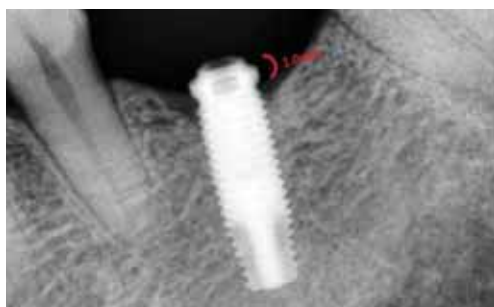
Periapical view. For a perfect guide to be screwed into the screw hole, an implant has to have at least 1mm of the screw threads on top of the fractured screw.
